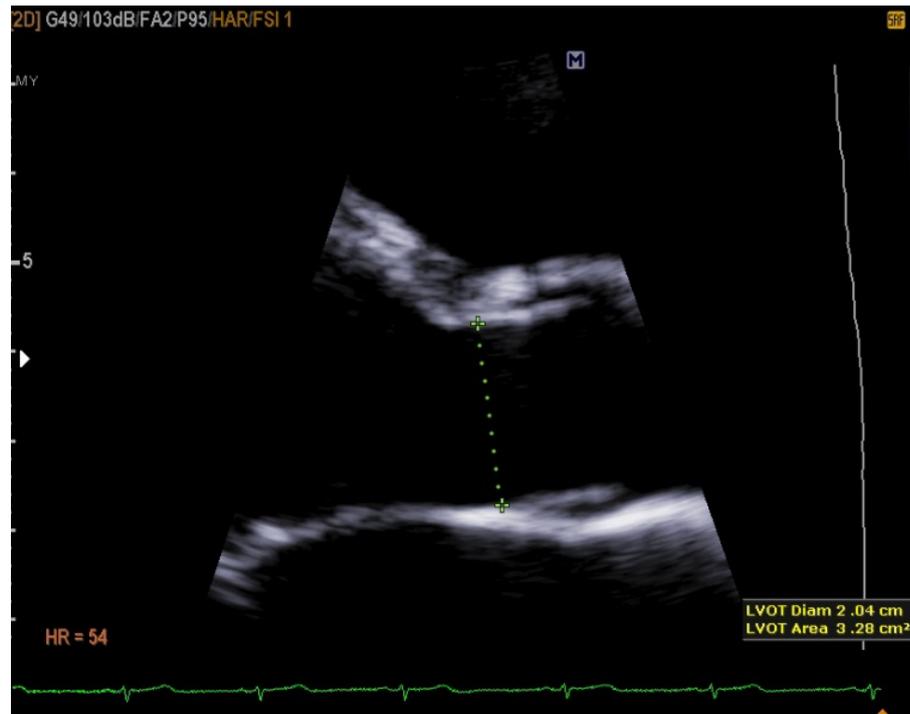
LVOT measurement from the parasternal long-axis view
